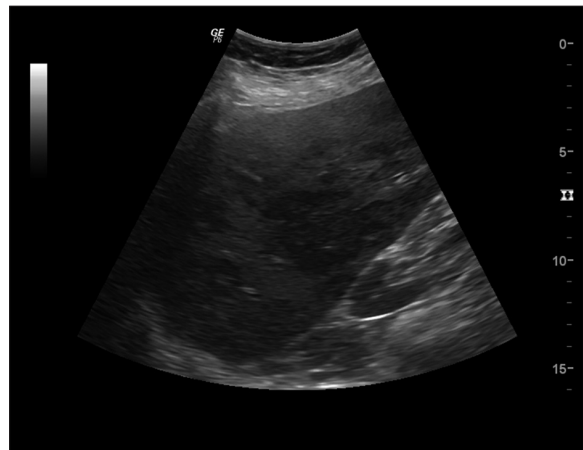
Trans-abdominal ultrasound showing multiple hypoechoic areas in the liver.
